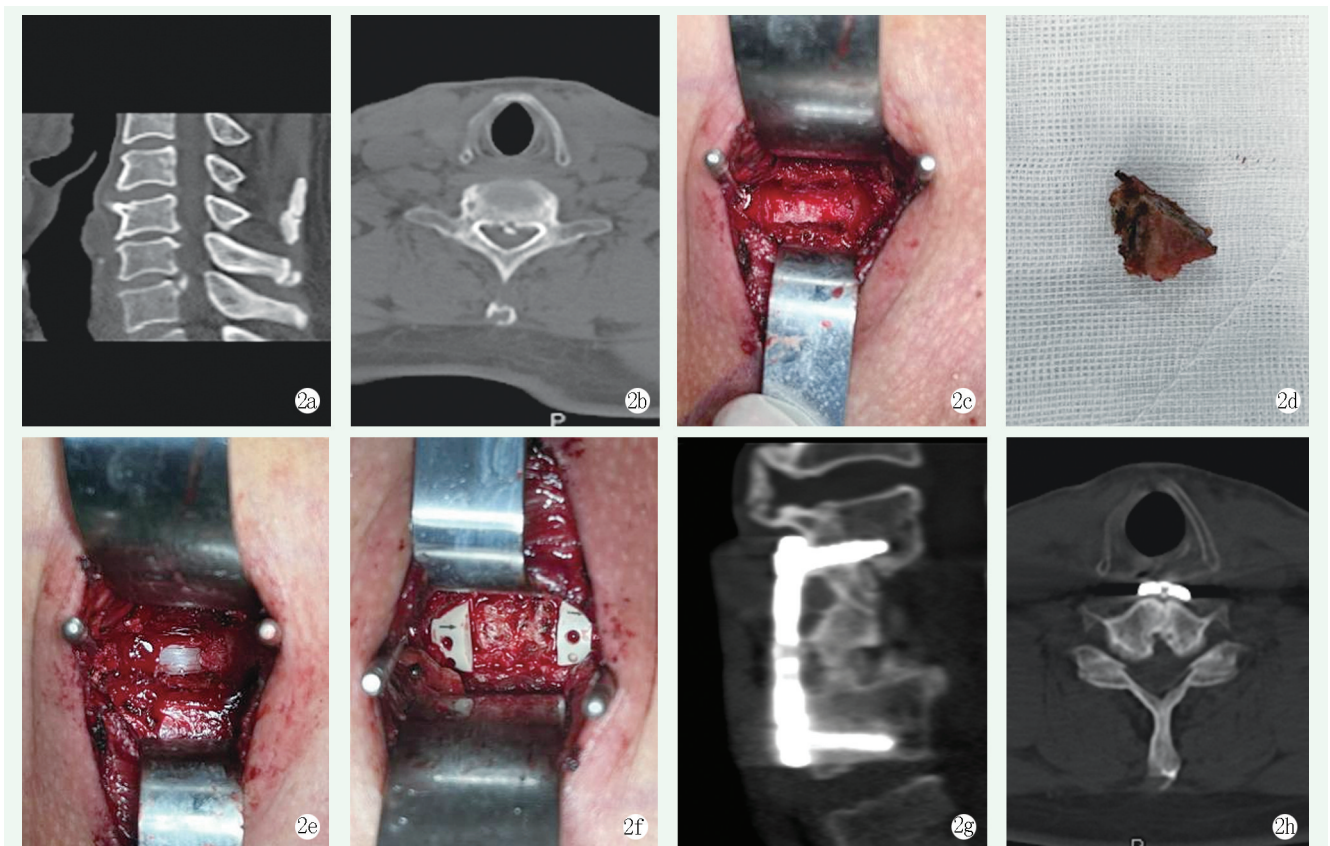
患者男性, 56 岁。2a, 2b: 术前 CT 显示 C<sub>5/6</sub> 节段周围脊髓受压, 骨赘增生严重, ACDF 减压困难; 2c: 处理上下椎间隙后行“V”形截骨; 2d: 截出的“V”形骨块; 2e: “Y”形减压暴露硬膜; 2f: 彻底减压后“V”形骨块回植并 Cage 置入; 2g, 2h: 术后 12 个月 CT 显示植骨融合牢靠, 融合区高度、颈椎生理曲度维持良好。
